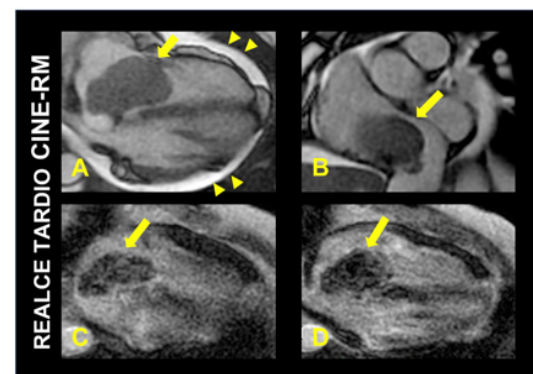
Cardiac magnetic resonance of 34-year-old female patient with a voluminous mass occupying the right atrium (arrows). A) Four-chamber cine magnetic resonance imaging scan showing a right atrial mass occupying part of the tricuspid valve plane during ventricular diastole and partially blocking the right ventricular inflow tract. This image also reveals discrete pericardial effusion (arrow heads). In B), short axis view of the right atrium depicts partial obstruction of inferior vena cava ostium by the atrial mass. C,D) Late enhancement images showing paramagnetic contrast uptake, which makes the diagnosis of intracavitary thrombus unlikely. Dynamic perfusion images of the mass (not shown) revealed signs of a highly vascularized structure, suggesting the diagnosis of malignant neoplasm. Image Courtesy of Dr. Tiago Augusto Magalhães.
